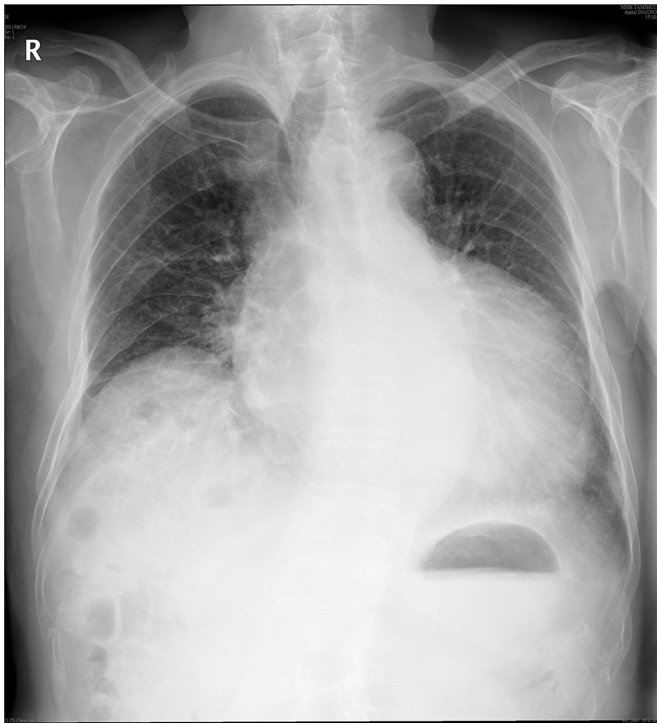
Chest X-ray reveals bottle-shaped and enlarged heart size.
